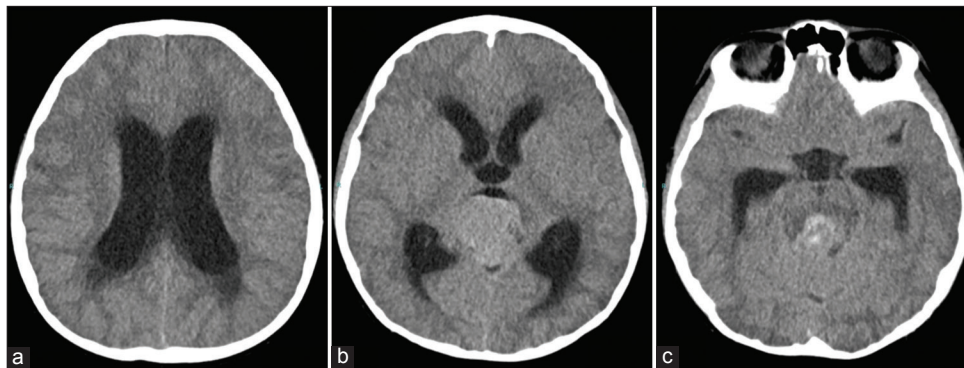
Preshunt computed tomography showed an isodense lesion in the pineal region with noncommunicating hydrocephalus, indicating a pineal region tumor. (a) View of lateral ventricle, (b) View of third ventricle, (c) view of temporal horn.
